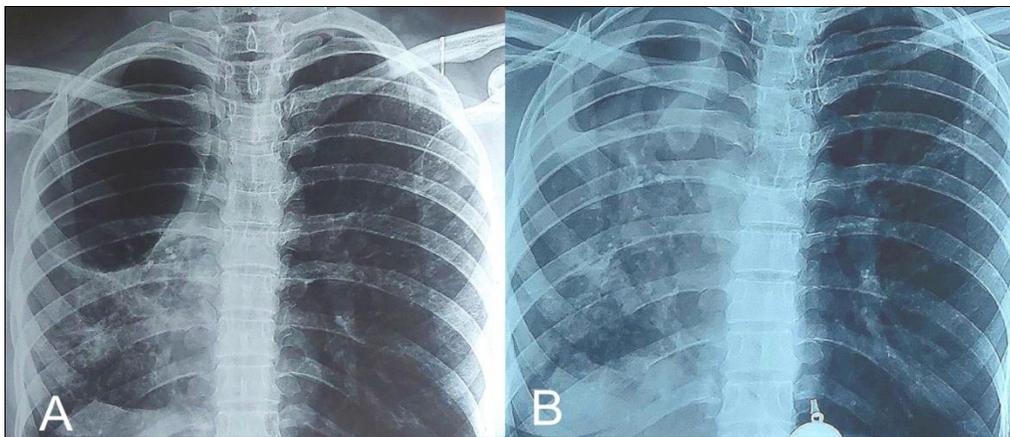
CXR representing different intervals of reduction in size of bullae. A= Preoperative Xray B= four weeks
